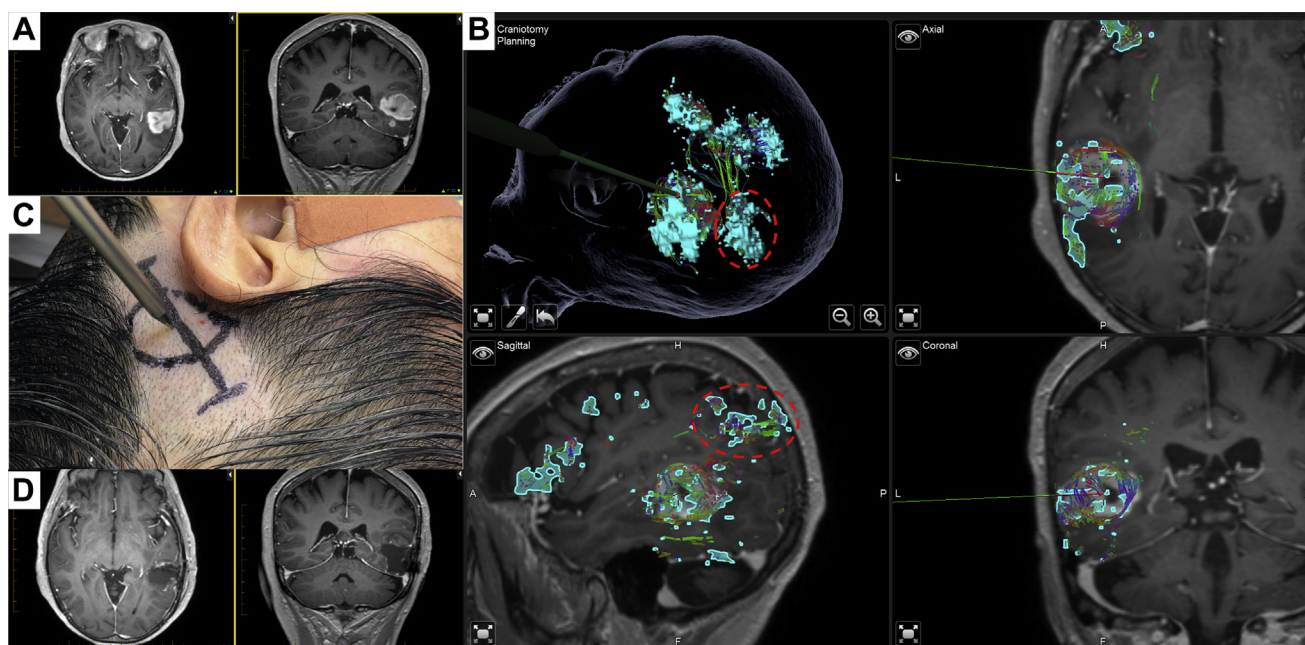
Resection of left posterior temporal glioblastoma. (A) Axial (left) and coronal (right) T1-weighted gadolinium-enhanced magnetic resonance imaging (MRI) demonstrates a gadolinium-enhancing mass in the left posterior temporal lobe. (B) Quicktome software applied to standard neuronavigation demonstrates language parcellations (aqua) encapsulated within the tumor mass (craniotomy planning view on top left, axial – top
